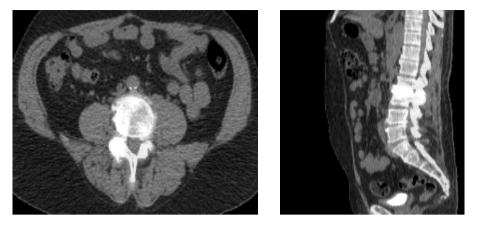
Male patient with persistent pain after previous laminectomy. The ¹⁸F-PET/CT images showed positive uptake at L3–L4 and in the right facet joint as well.
